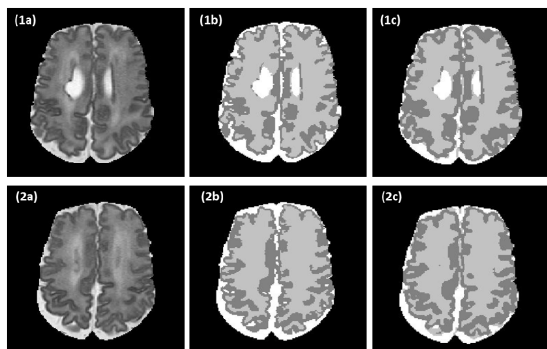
(a) ELBW T2-weighted images; segmentations by (b) manual expert; and (c) proposed method.
